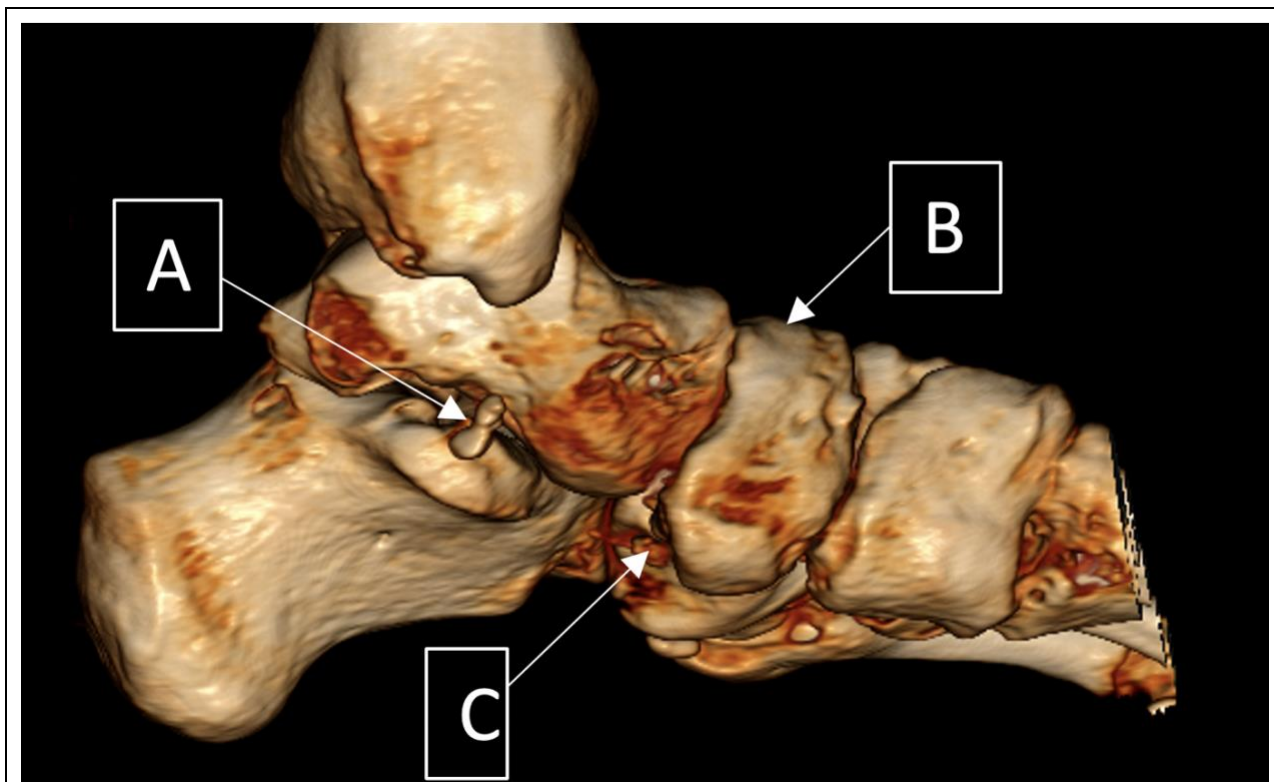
Preoperative CT scan with 3D reconstruction at day 21.
